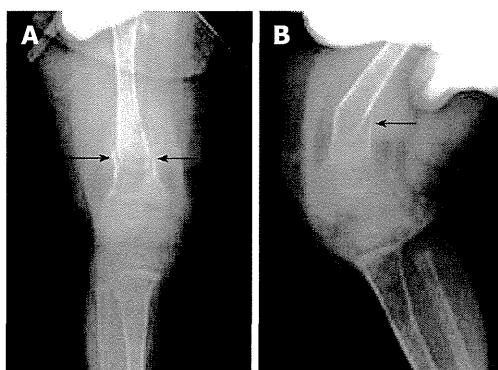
Plain skeletal radiographic features at the 7 d after hepaticojunostomy in the case 1. Anteroposterior (A) and lateral (B) plain radiographs showing a displaced fracture (arrows) of the right distal femur.
